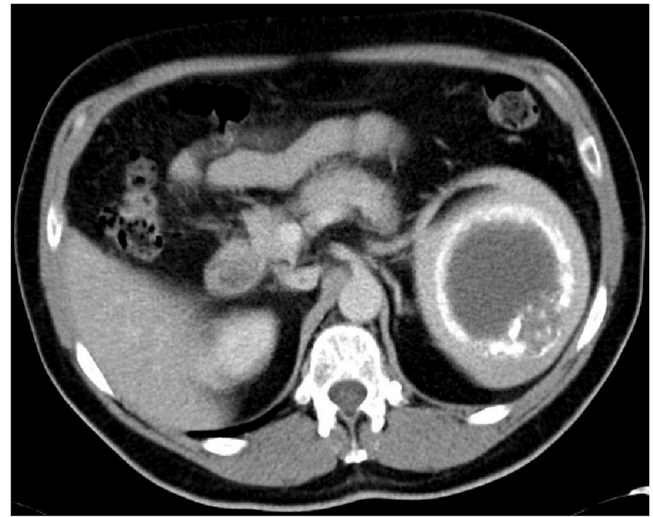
CT slice of the lower edge of the cystic lesion; a smaller, more heterogenous lesion is noted with dimensions of 4.3 × 2.7 × 4 cm.
